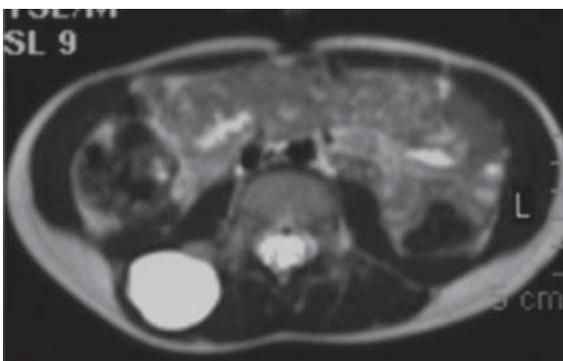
MRI demonstrating a 3x3.5x3 cm cystic lesion inside the right back muscles.
